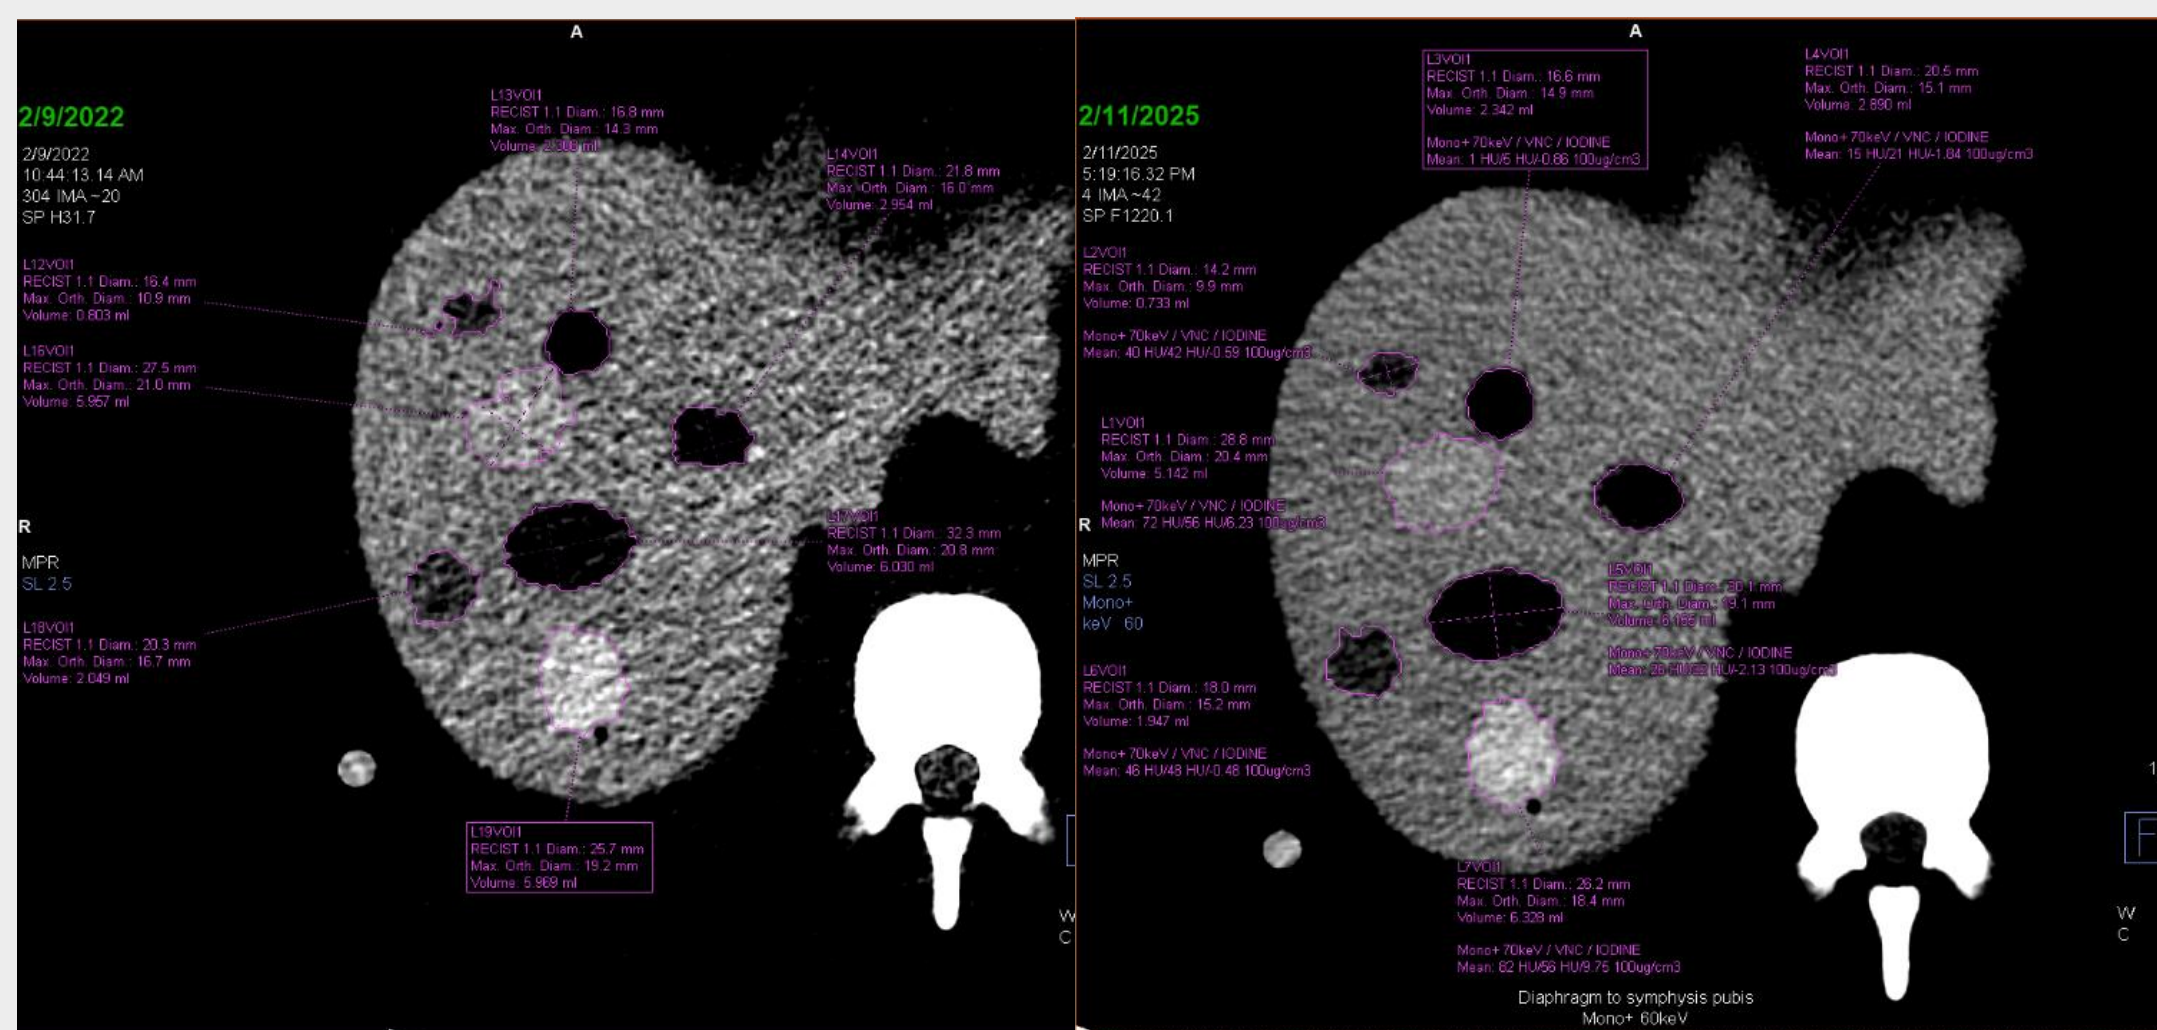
Sample lesion segmentations at 60 keV. Dual energy CT (left) and PCCT (right)
